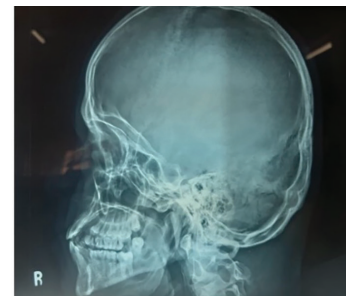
Radiograph of the Posterior-Anterior and Lateral View of the Skull With Calcification of Bilamellar Falx Cerebri
